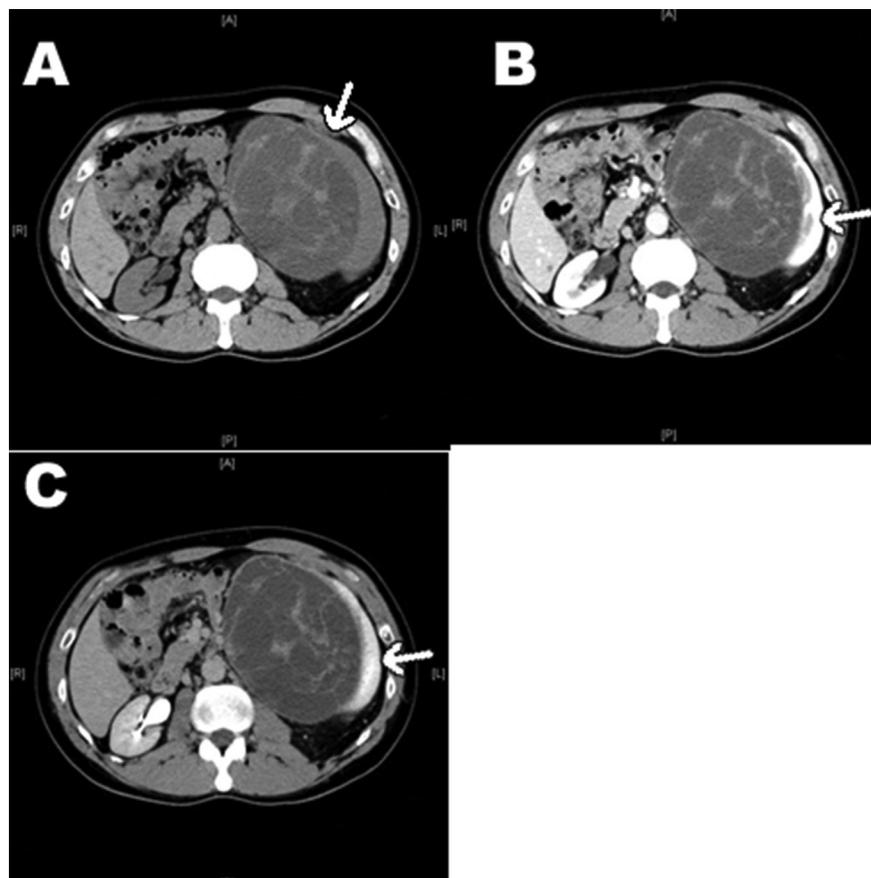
Abdominal computed tomography showed the tumor (white arrow) had heterogeneous soft tissue with calcification and multiple septa in non-enhanced phase (A). The solid part had enhancement in arterial phase (white arrow) (B) and in secretory phase (white arrow) (C).
